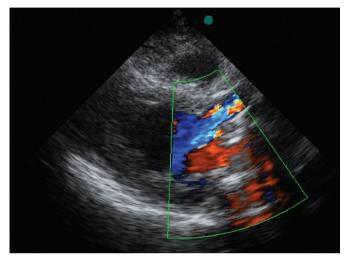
Long axis view of transthoracic echocardiography shows severe aortic regurgitation.
